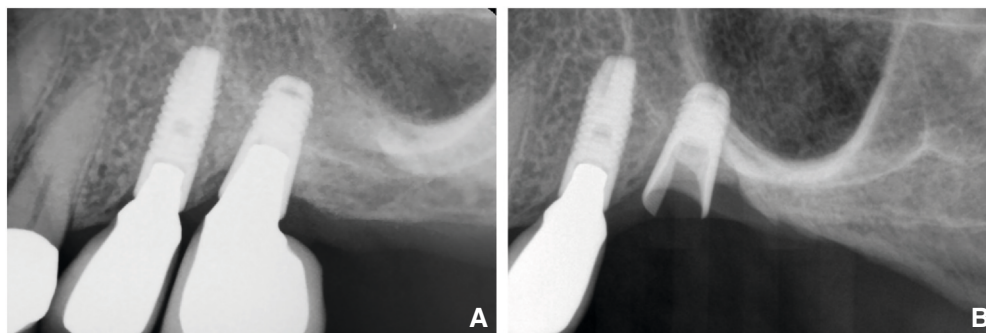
Periapical radiographs of patient who experienced FOI. A, Two implant-supported crowns inserted on implants replacing maxillary left second premolar and first molar. B, Implant supporting maxillary left molar fractured associated with off-axial loads and parafunction. FOI, Fracture of osseointegrated implant.
